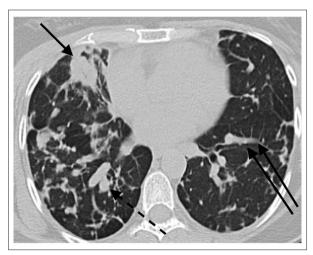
Computed tomography thorax showing a right apical mass (solid arrow) and diffuse reticulonodular infiltrates (dotted arrow) with intraseptal thickening (2 arrows).
